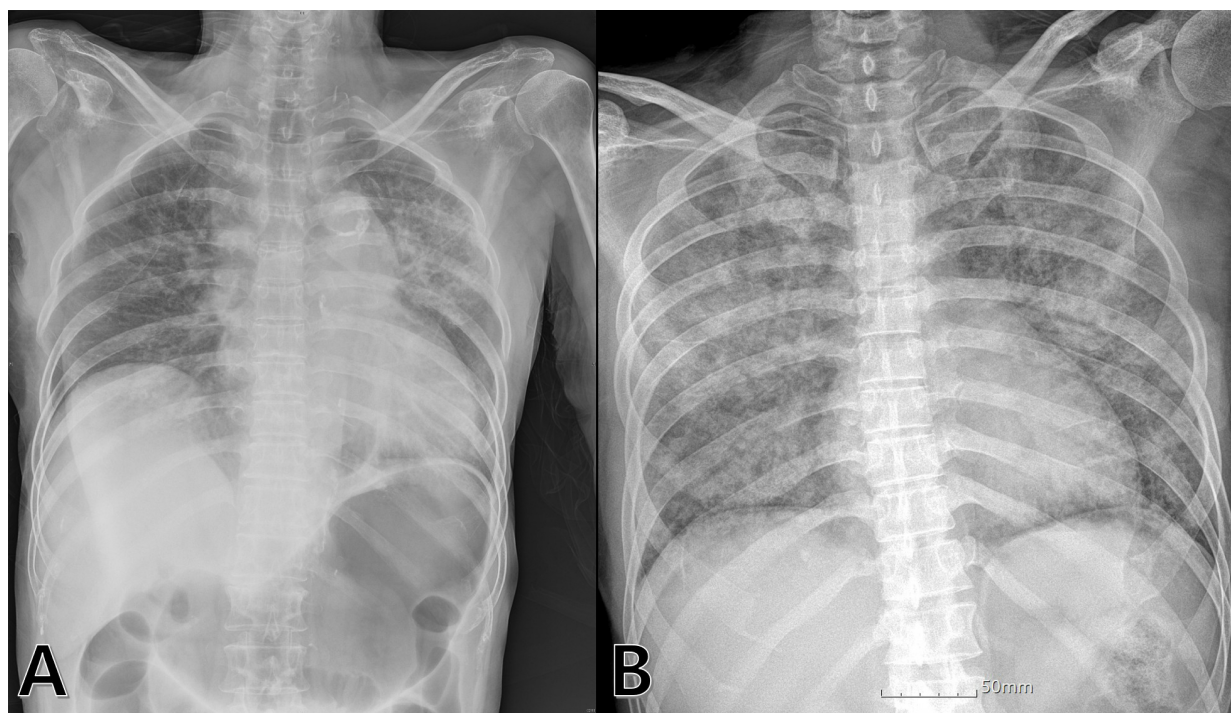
An example of a plain chest radiograph with (A) and without (B) gastric inflation after prehospital resuscitation.
